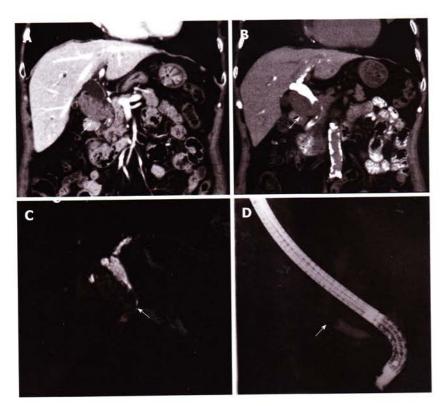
A 79-year-old female presented to our hospital for an incidentally-diagnosed gallbladder tumor. A: Coronal contrast-enhanced computed tomography (CT) image. The white arrow points to the gallbladder tumor with bile duct tumor thrombus; B: Coronal drip infusion cholangiographic CT image. The white arrow indicates the gallbladder tumor with bile duct tumor thrombus; C: Endoscopic retrograde cholangiopancreatography image. The white arrow indicates the defect due to the bile duct tumor thrombus; D: Magnetic resonance cholangiopancreatography image. The white arrow indicates the defect due to the bile duct tumor thrombus.
